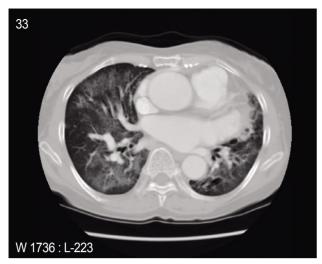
Computed tomography of the lung showed new bilateral patchy ground-glass opacities and underlying bronchiectasis.
